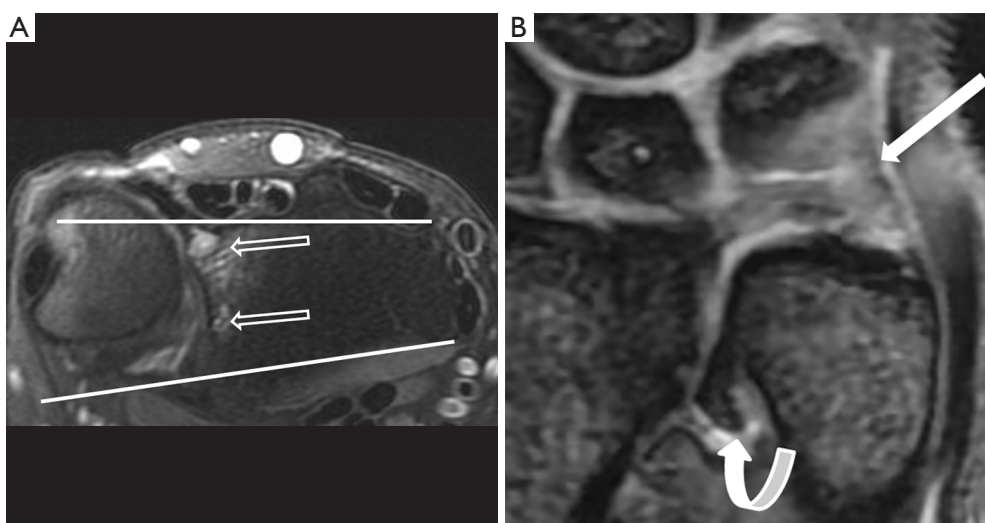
Dorsal subluxation of the DRUJ. (A) Axial proton density fat-suppressed MR image. There is dorsal subluxation of the distal ulna at the sigmoid notch associated with moderate subchondral cystic changes (block long arrows) of the radius; (B) coronal proton density fat-suppressed MR image of another patient showed an ulnar-sided tear of the TFCC (solid long arrow). There is severe degeneration of the DRUJ with osteophytes (solid curved arrow) and joint effusion due to chronic DRUJ instability. TFCC, triangular fibrocartilage complex; DRUJ, distal radioulnar joint.
